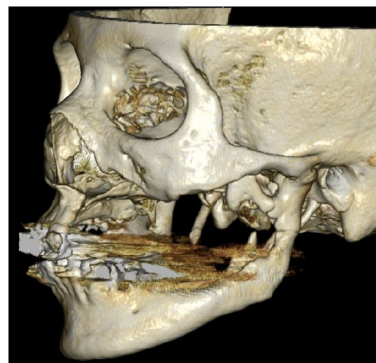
3D CT imaging findings at 12 months postoperatively. Mandibular bone had grown over time
